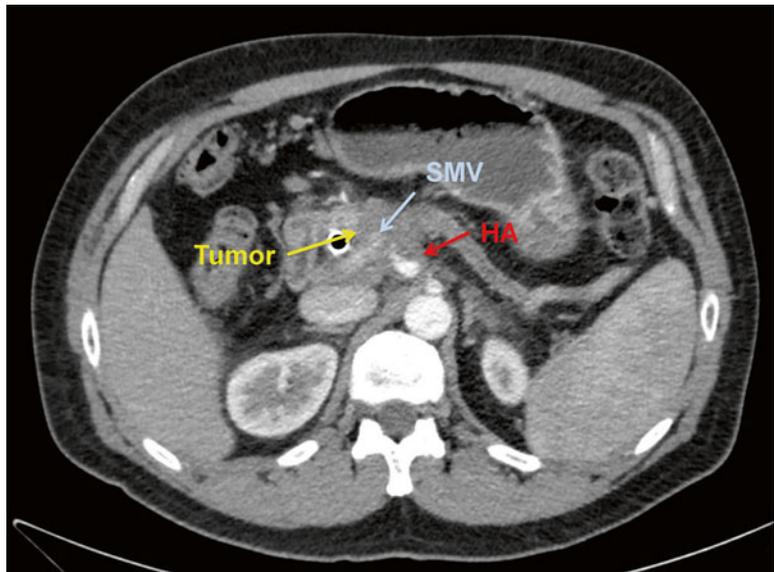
CT scan of a locally advanced pancreatic adenocarcinoma with encasement of the SMV as well as the CHA (common hepatic artery)
